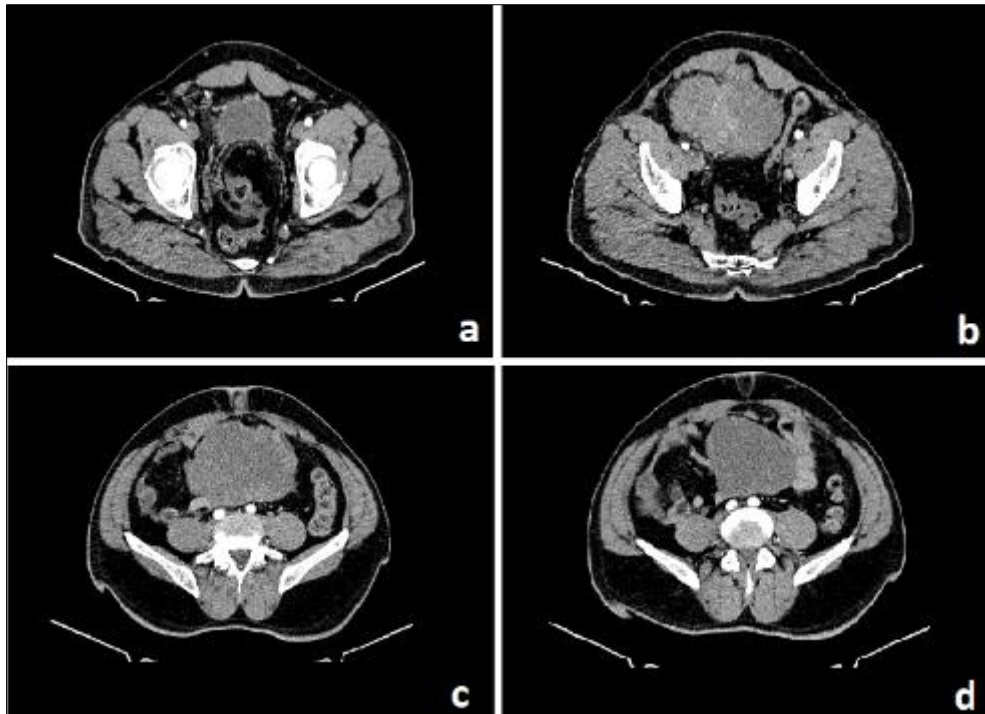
Axial section of an abdominopelvic CT scan showing an exophytic development of PNET
